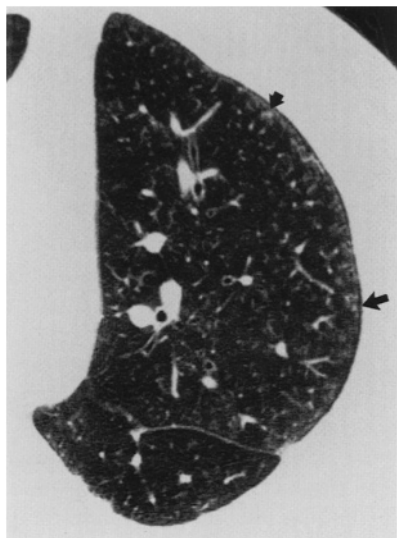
HRCT scan of asbestosis. Thickened intralobular core lines. The subpleural lesions appear as dotlike structures a few millimeters from the pleural surface (*arrows*)
